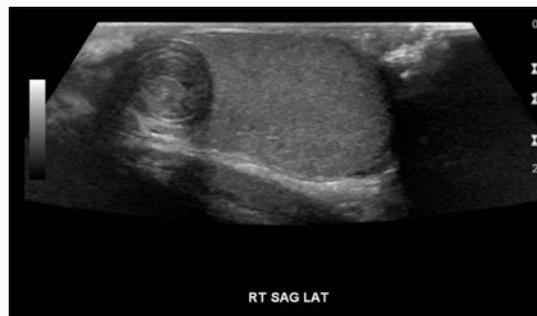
High-frequency linear array ultrasound image demonstrating a 1.4 × 1.3 mass in the superior pole of the right testicle.
